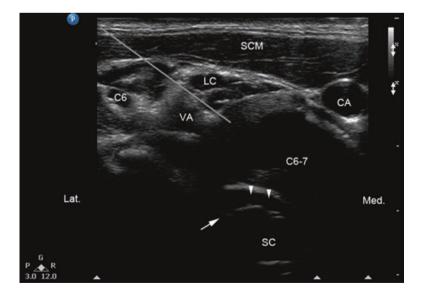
Short-axis sonogram showing the trajectory of the needle for C6–C7 diskogram. CA internal carotid artery, VA vertebral artery, C6 C6 nerve root, C6–C7 C6–C7 disk, SC spinal cord. Arrowheads pointing at the anterior epidural space posterior to the disk and solid arrow pointing at the origin of C7 nerve root. (Reprinted with permission from Ohio Pain and Headache Institute)
